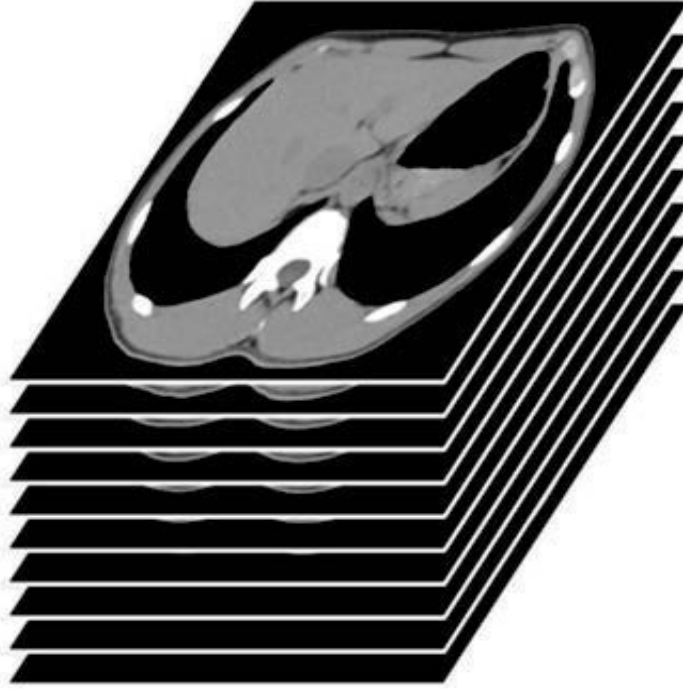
CT images for the airway tree volume segmentation
